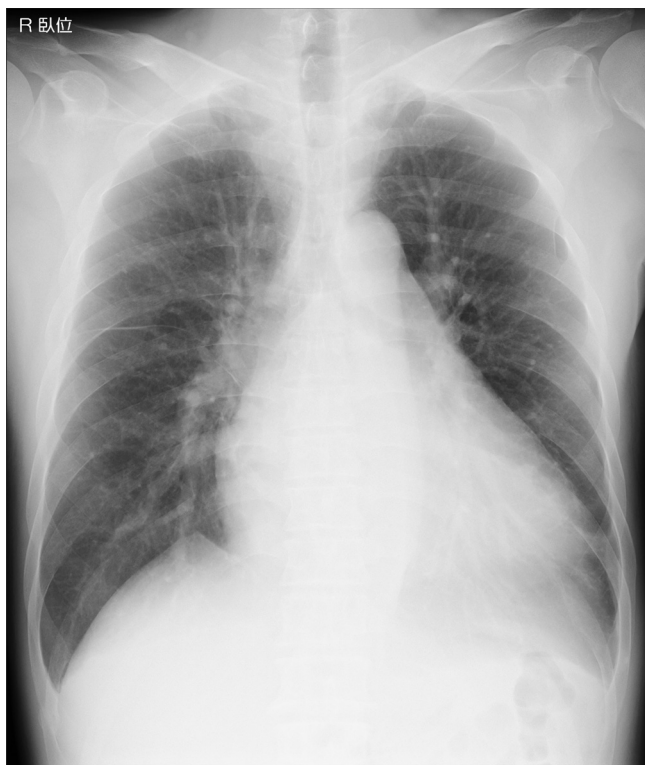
An initial portable chest radiograph postoperatively showed right-sided patchy opacities and interstitial infiltrates.
